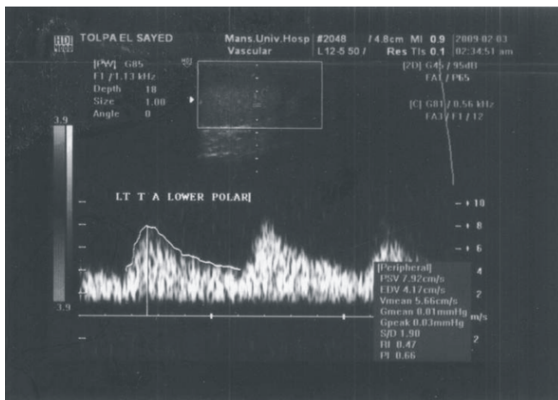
Doppler image of left testicular artery lower polar.
